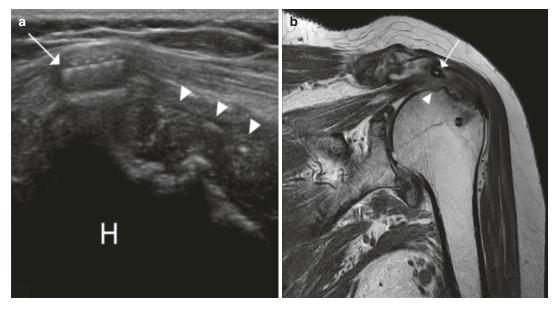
Failed cuff repair due to implant pull-out. (a) Longitudinal B-mode ultrasound and (b) coronal oblique PD-weighted MRI images of the same patient post supraspinatus tendon repair. Fractured tendon anchor (arrows)
